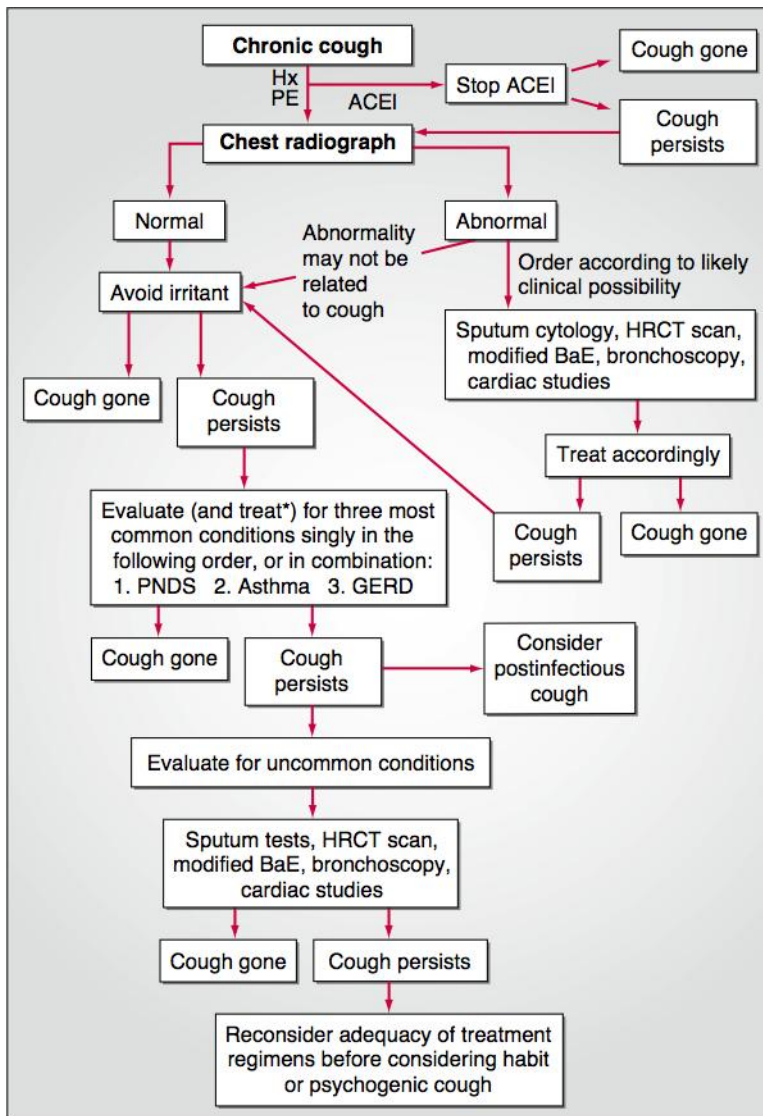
An algorithm for the evaluation of chronic cough. ACEI, angiotensin-converting enzyme inhibitor; BaE, barium esophagography; GERD, gastroesophageal reflux disease; HRCT, high-resolution CT; Hx, history; PE, physical examination; PNDS, postnasal drip syndrome.
